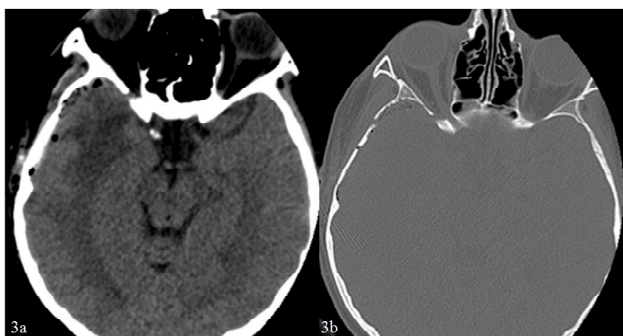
Craniotomy area related with the operation in the temporal bone where the subdural-epidural empyema was evacuated is shown in the post operational parenchymal and bone window axial sections of CT (3a & 3b).
